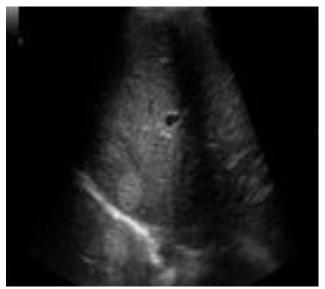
Abdominal ultrasound scan with metastatic foci in the liver of the patient
